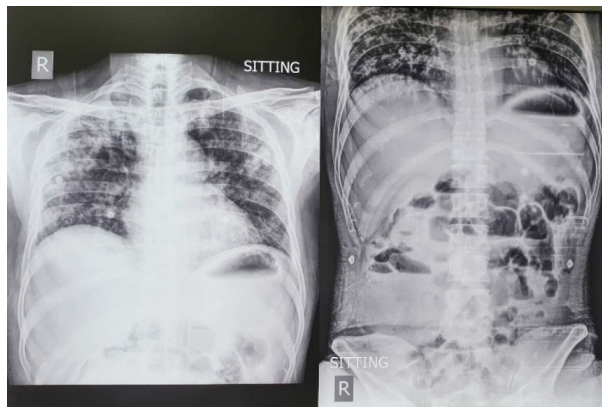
Chest Xray- multiple air fluid levels.
